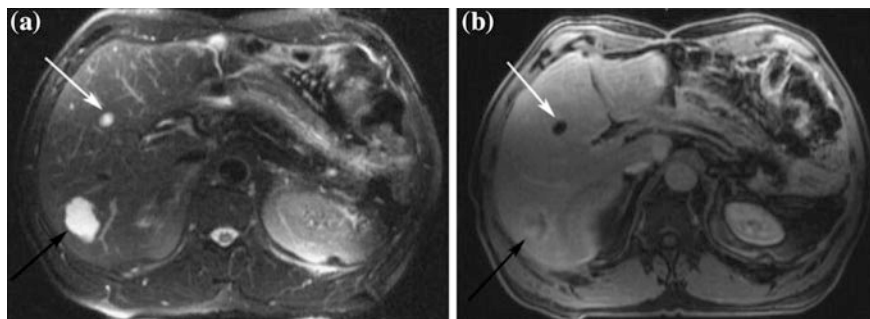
Distinction between metastasis and focal nodular hyperplasia, thanks to a liver contrast agent (Gd-EOB-DTPA) by MRI (T_1 -weighted FLASH sequence, fast low angle shot) 3D. During the arterial phase of the contrast agent, two hypervascular lesions are visible (*white arrow*) in a patient with a clinical history of breast cancer (a). During the hepatospecific phase of Gd-EOB-DTPA (20 min after injection), MRI showed a “wash-out” of the contrast agent in the area indicated by the *white arrow*, corresponding to metastasis. During this same phase, the region indicated by the *black arrow* has captured the contrast agent homogeneously with a better definition of a central scar characteristic of a focal nodular hyperplasia (b). The nature of these lesions was confirmed after surgical resection of metastasis and biopsy of the focal nodular hyperplasia. Figure reproduced with permission of Ref. [27]
